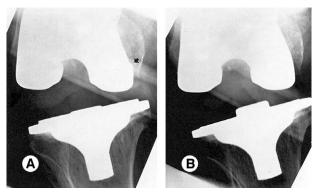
Varus stress radiograms with two different projections of the femoral component. (A) The dorsal end of the femoral component forms a sharp convex contour (arrow) indicating insufficient positioning of the thigh in the adduction-abduction plane for a strictly sagittal radiograph. (B) The sharp convex contour has disappeared indicating correct positioning.
